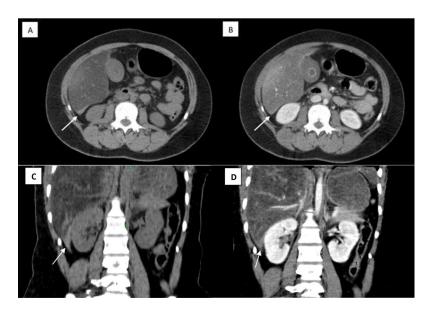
Hemoperitoneum (white arrow) in a case of severe fatty liver: Hyperdensity hemoperitoneum in non-contrast CT appearing isodensity to hepatic parenchyma after contrast-enhanced CT. (A) Non-contrast axial view. (B) Contrast-enhanced axial view. (C) Non-contrast-enhanced coronal view. (D) Contrast-enhanced coronal view.
